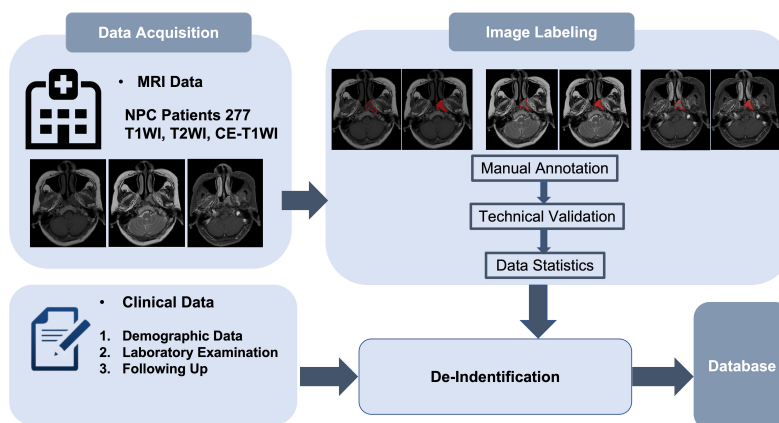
Graphic abstract and showcase. The MRI showcases a patient’s MRI imaging including T1WI, T2WI, and CE-T1WI sequences, which were processed by the manual annotation with labeled tumor boundaries and highlighted areas, respectively.
